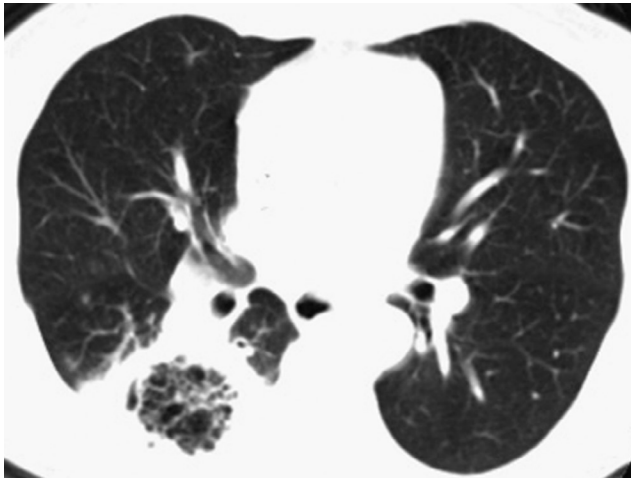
Mucormycosis. Radiograph showing pulmonary infarction of the right lower lobe in a diabetic patient with pulmonary mucormycosis.
